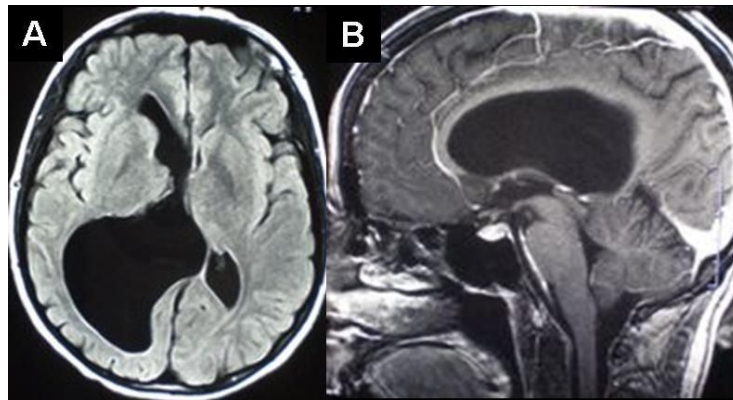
Brain MRI before endoscopic surgery (A axial slice, B sagittal slice)
